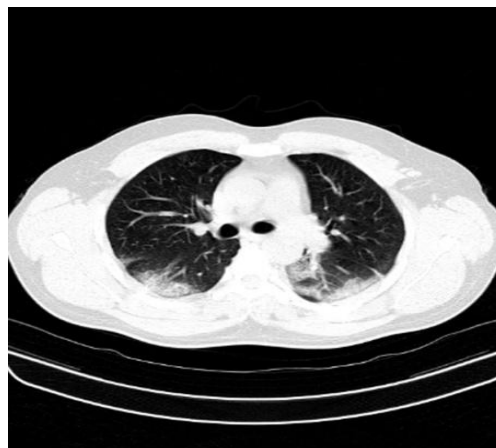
CT Thorax showing mild bilateral lower lobe Ground glass opacity
